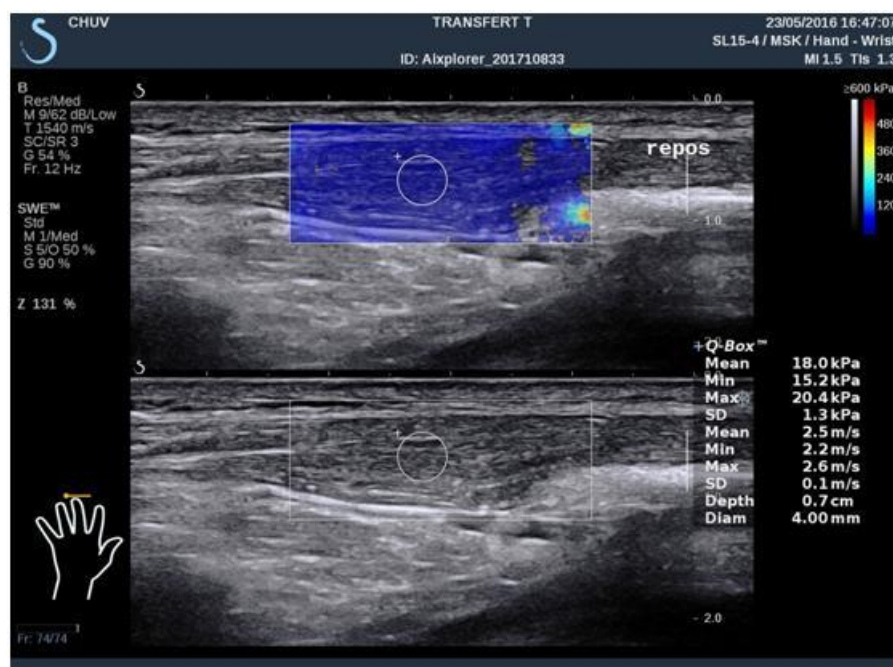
B-mode ultrasound (low) and elastographic (high) recording during the 1st stage of the transfer (R).
